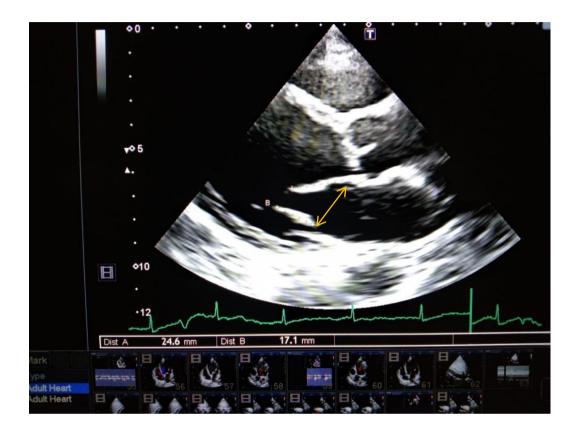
Echocardiographic image measuring an annular diameter in the parasternal long-axis view from the current study.
